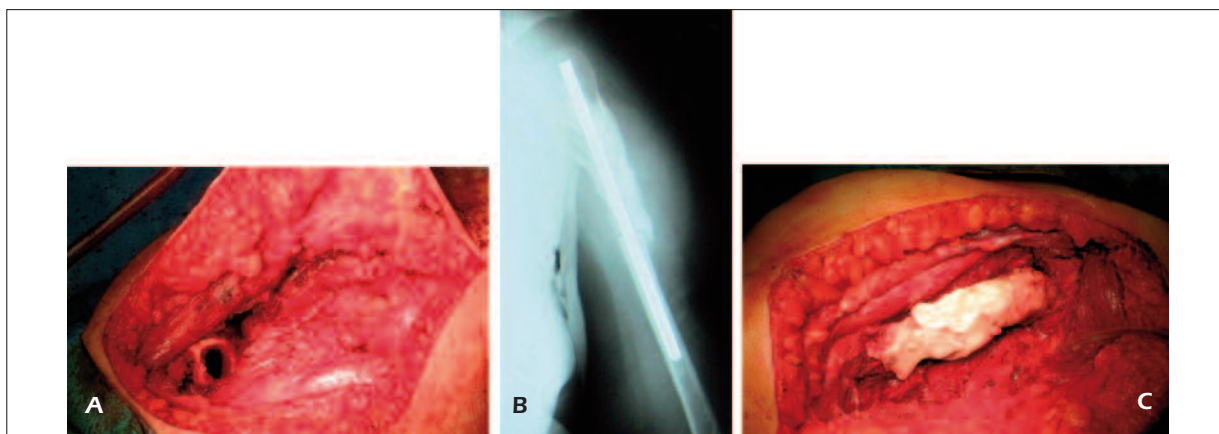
A*, Intraoperative aspect of a removed fibrosarcoma of the left humerus. *B*, AP radiograph with the cement spacer in situ over a short intramedullary nail. *C*, Final intraoperative view with the PMMA in place.
